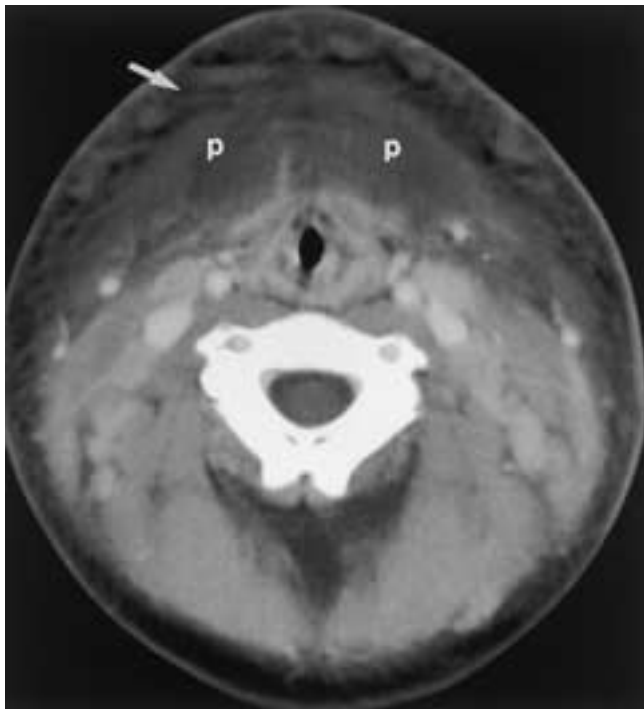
Streptococcal necrotizing cellulitis in a 2-year-old girl with a 6-day history of chicken pox and a 2-day history of rapidly progressive facial swelling. Contrast-enhanced CT shows massive swelling of the neck, diffuse stranding of the subcutaneous fat (*arrow*), low-attenuation phlegmonous change (*p*), and blurred muscle margins. The airway is narrowed.
